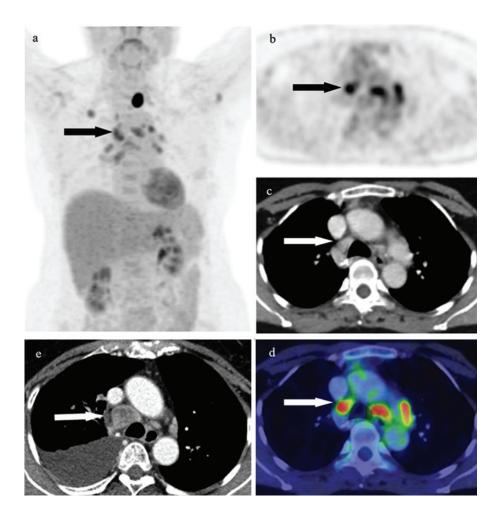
Metastatic lymph node: A 60-year-old female with stage IIIC colon cancer status post right hemicolectomy, with adjuvant chemotherapy presented with rising serum carcinoembryonic antigen. Fluorine-18 fluorodeoxy-glucose positron emission tomography/computed tomography, showed multiple fluorodeoxyglucose-avid mediastinal lymph nodes. The most intense lymph node is at the right paratracheal region, with maximum standardized uptake values of 6.6 and lymph node-to-liver ratio of 2.2 (3a, 3b, 3c, 3d). A follow-up diagnostic chest computed tomography showed an increase in size of the lymph node from 1.2 to 2.5 cm (108% change from baseline), with internal necrosis (3e). The left thyroid nodule with intense fluorodeoxyglucose uptake is noted (3a).
